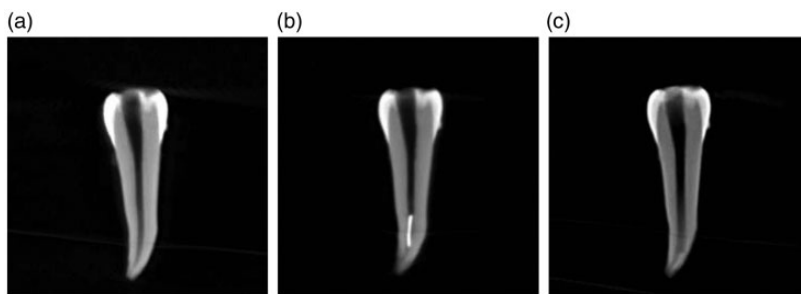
Cone-beam computed tomography images. (a) Preoperative radiograph of the mandibular first premolar; (b) Radiograph of a fractured NiTi endodontic instrument in the root canal; and (c) Postoperative radiograph of the mandibular first premolar
